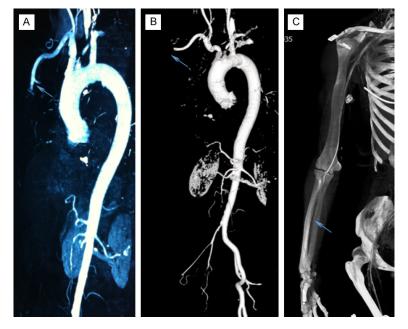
Preoperative CTA results of patient 1, 4, and 5. A-C: CTA showed thrombosis and occlusion of axillary artery (arrow) in patient 1 and patient 4 respectively, and occlusion of radial artery in patient 5.
